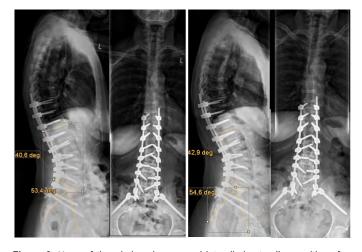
X-ray of the whole spine a.p and laterally in standing position after 3 months and 6 months postoperatively shows no loss of correction and no material failure
